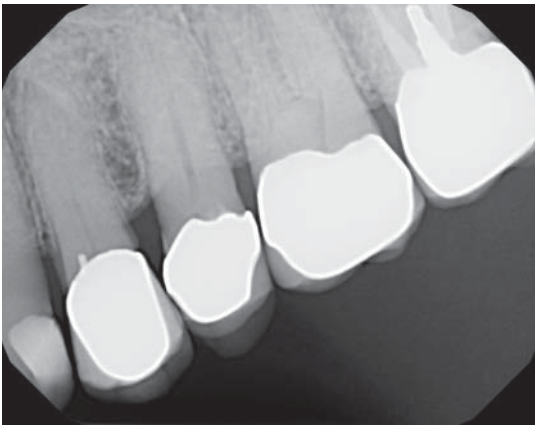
Pretreatment radiograph of tooth #12.
